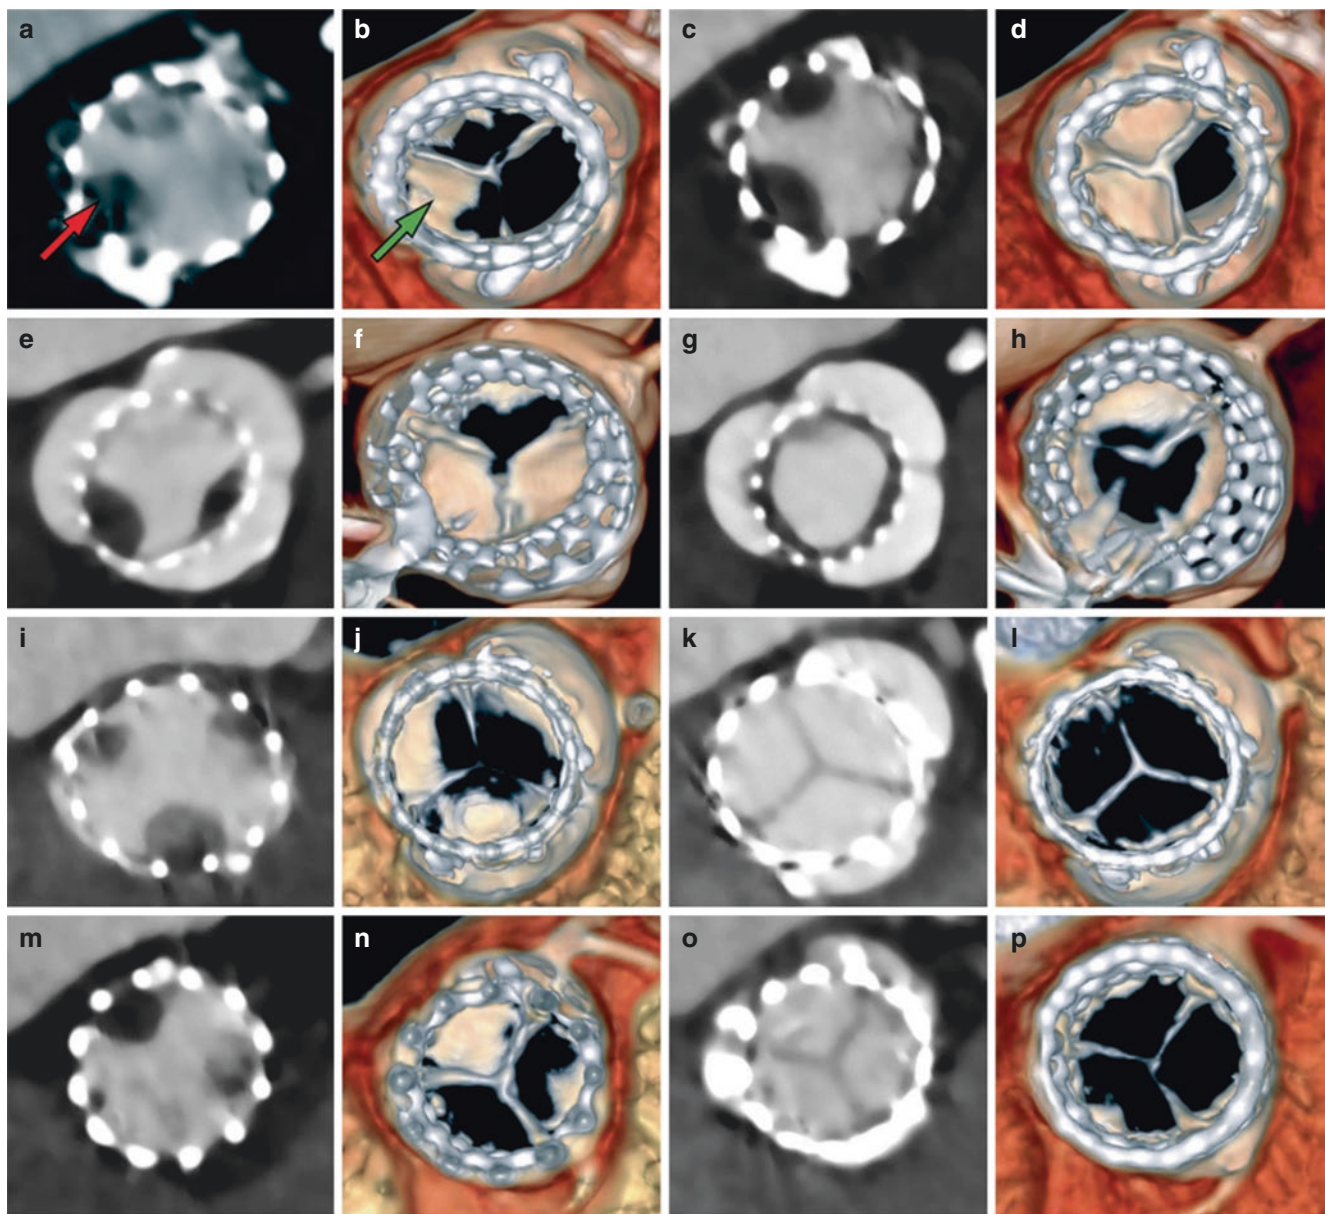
Effect of dual antiplatelet therapy versus anticoagulation on hypoattenuating opacities and reduced leaflet motion. (a–d) Reduced leaflet motion at baseline, noted to have worsening hypoattenuating opacities and reduced leaflet motion with follow-up CT in a patient receiving dual antiplatelet therapy after transcatheter aortic valve replacement.
